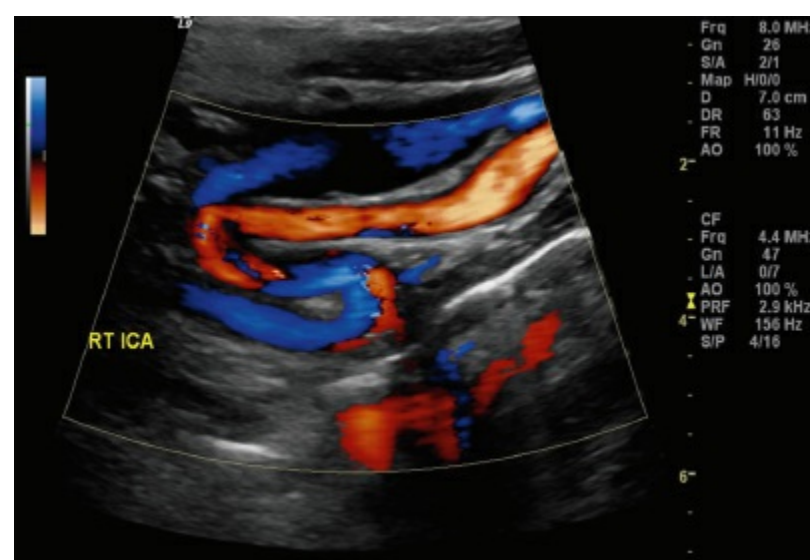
Duplex ultrasonography with color shows an extremely tortuous internal carotid artery.
